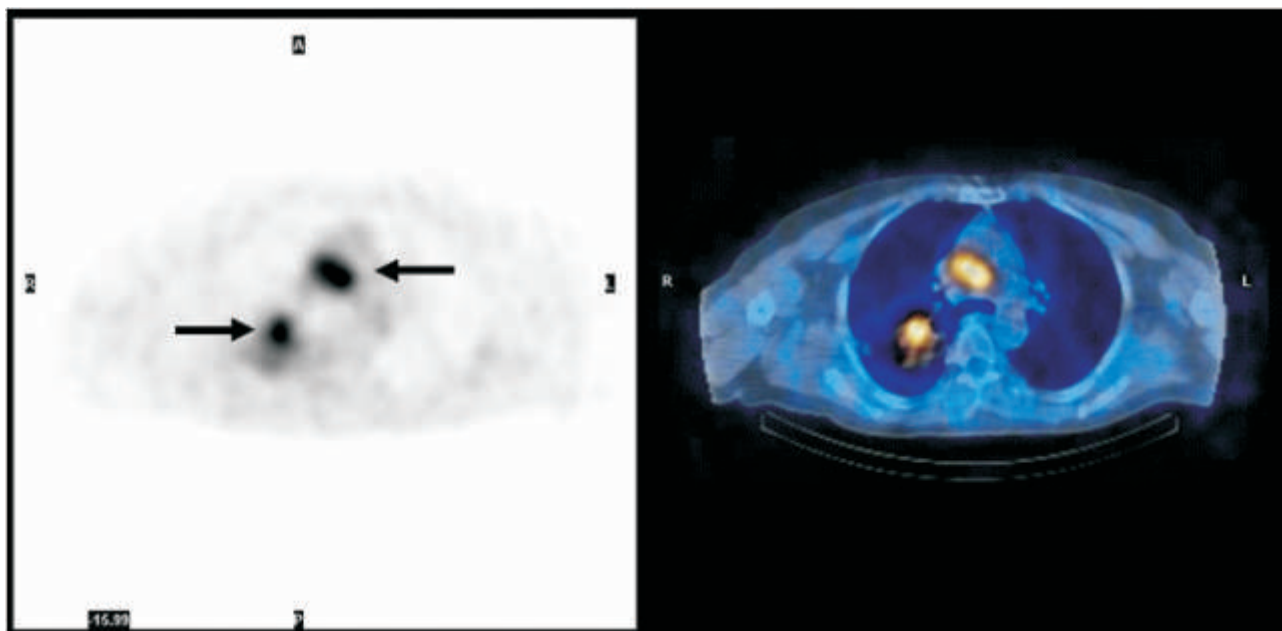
GC-PET / CT images. Left, a trans-axial slice showing abnormally raised FDG uptake in a primary lung tumour and mediastinal lymph nodes (arrowed). Right, GC-PET images of the same patient co-registered with low-resolution CT for anatomical localisation.
